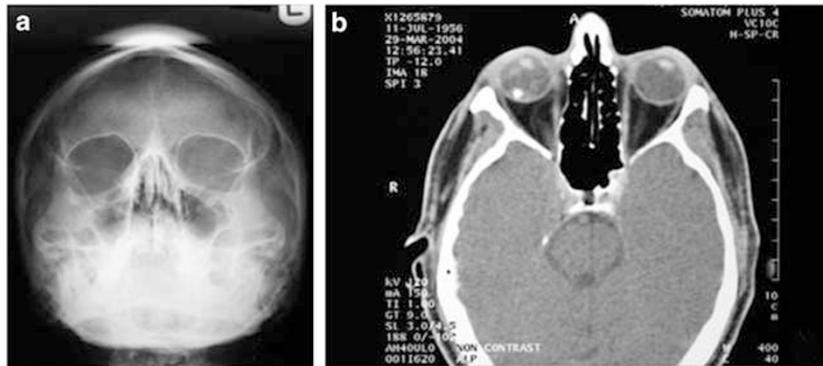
(a) Orbital X-ray. (b) CT scan showing a right intraocular foreign body.
